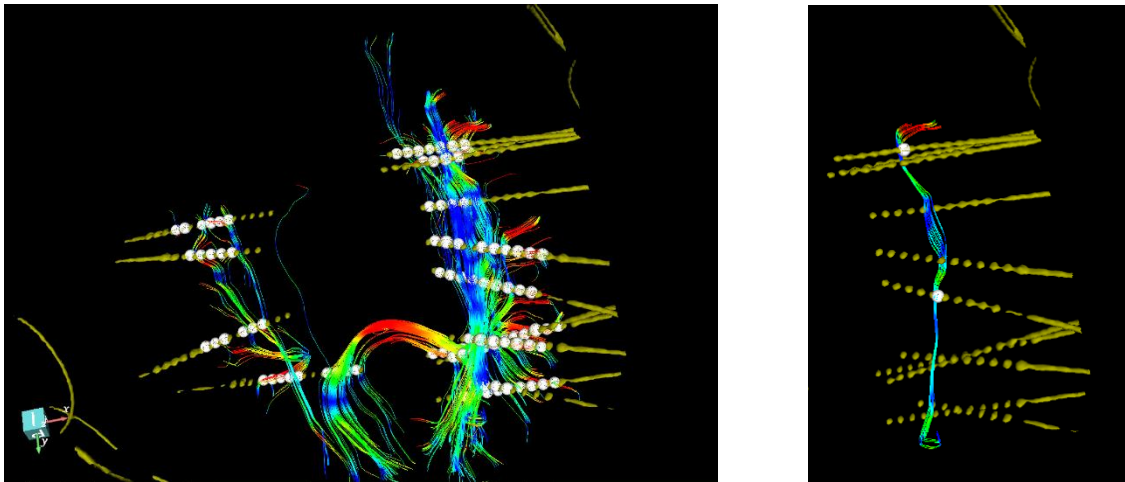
SEEG-Electrome computation of a patient with bilateral implantation of SEEG electrodes. Left: aggregated result of the computation. Right: single result from a pair of bipolar spherical ROIs (from SEEG) and the tracts which connect them anatomically (according to the DWI tractography).
